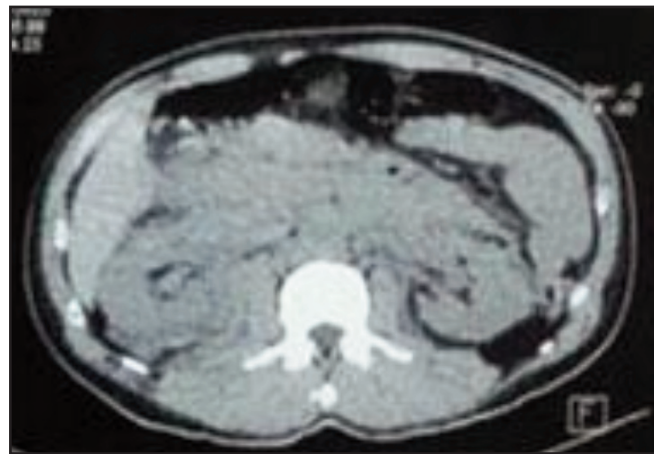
Plain axial CT scan with presence of hematoma in retroperitoneum.
